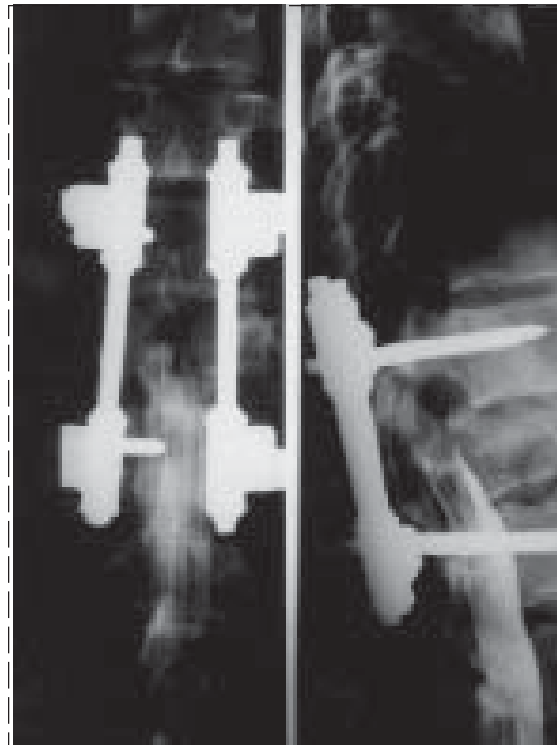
Persisting bony impingement of the cauda equina. This 36-year-old male fell about 100 feet, landing on his buttocks, when his parachute partially collapsed. He was immediately paraplegic and radiographs revealed an L-1 burst fracture. An L-1 laminotomy, decompression of a retropulsed bony fragment and posterior Synthes instrumentation were performed. By two months some strength had returned in the lower extremities and ambulation training began in physical therapy; however, serial Cybex testing revealed worsening of his hamstring strength and repeat peroneal F-wave latencies, and motor evoked potential (MEP) latencies became more prolonged. The above lumbar myelogram was obtained and revealed a persisting complete block to dye flow at L-1 and inadequate bony decompression of the cauda equina. The patient was referred to orthopedic surgery for an anterior decompression; he subsequently regained functional strength in his lower extremities, becoming ambulatory without aids except for bilateral ankle-foot orthoses.
